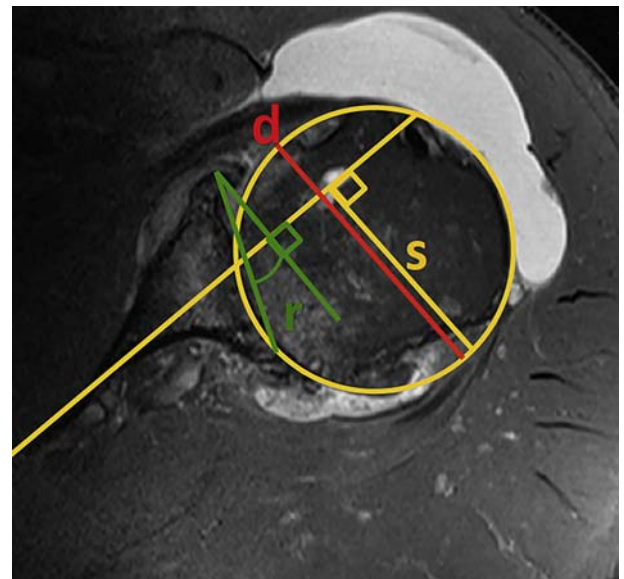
Axial magnetic resonance image of a preoperative B2 glenoid. The retroversion (r) was measured from a line perpendicular to the plane of the scapula (Friedman line).^{4,5} Posterior decentering compared the diameter of the humeral head to a line along the scapula axis to give a percentage of decentering ($s/d \times 100\%$).¹¹
